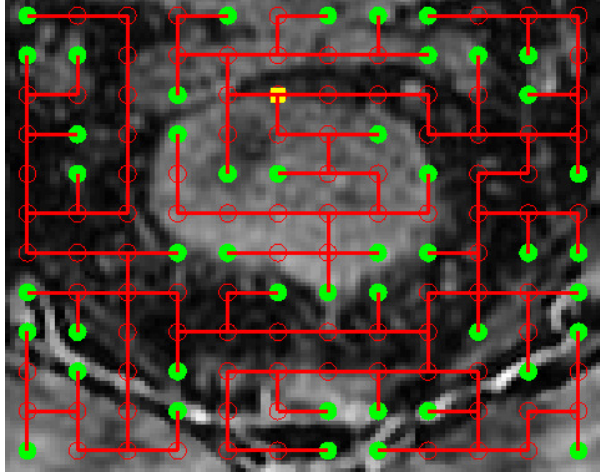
The MST corresponding to a 2D slice from a DCE-MRI image of the mesorectum. The leaf nodes are represented in green, and the root is represented in yellow.*
